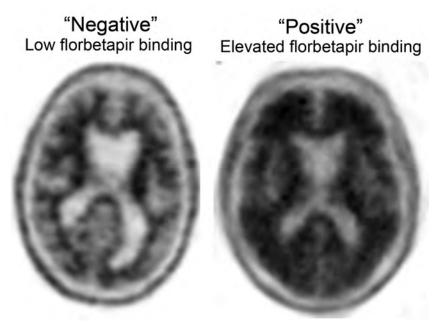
Assessment of amyloid deposition by use of florbetapir (Amyvid). The axial PET image on the left shows normal preserved gray-white contrast with the cortical radioactivity less than the adjacent white matter (amyloid-"negative" scan). The axial PET image on the right demonstrates areas of decreased gray-white contrast with increased cortical radioactivity that is comparable to the radioactivity in the adjacent white matter (amyloid-"positive" scan). The florbetapir scan on the right was acquired on a patient with MCI who clinically progressed to dementia with a high biomarker probability of AD, as supported by this amyloid-positive scan and evidence of neuronal injury on structural MR imaging (Fig 1).
